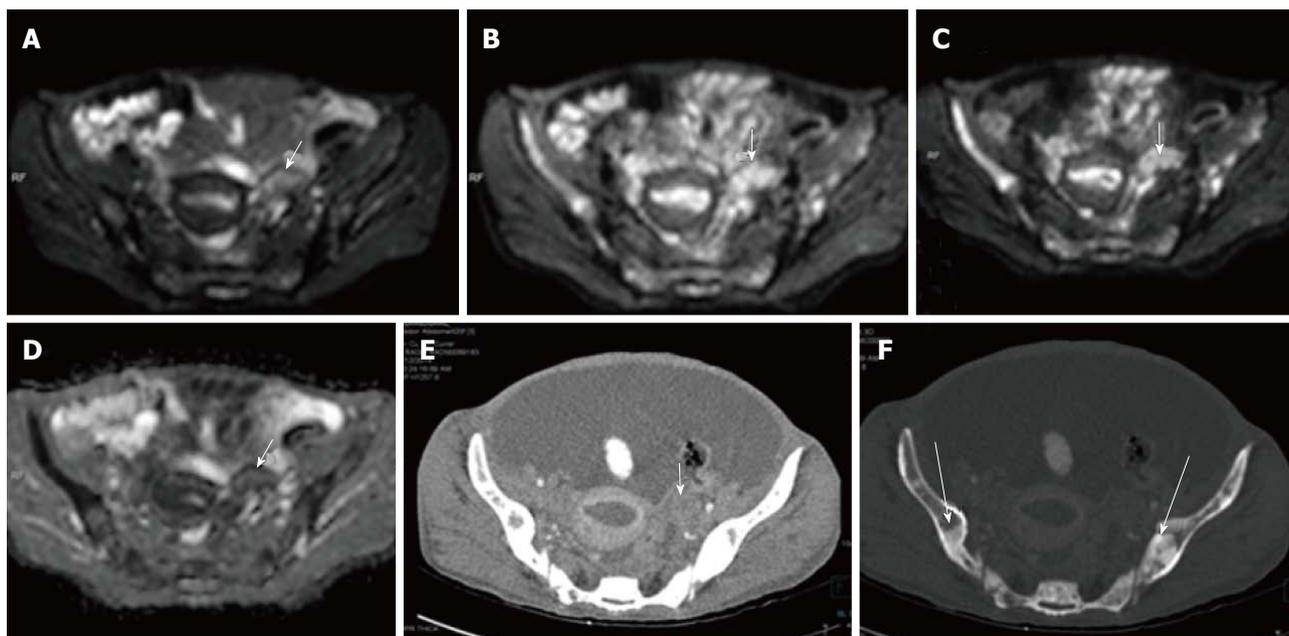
Left ovarian metastasis. Axial diffusion weighted imaging b 0 (A), b 400 (B), b 800 (C) and ADC (D) images of known case of carcinoma breast shows significant restricted diffusion of the left ovarian mass (arrow) suggesting left ovarian metastasis. Note is also made of multiple hypointense diffusion restricting lesions in the b/liliac bone which were metastatic deposits. Axial contrast enhanced CT (E) showing the left adnexal mass (arrow) with multiple sclerotic metastases (thick arrows) in bilateral iliac bones better seen on CT bone window image (F). ADC: Apparent diffusion coefficient; CT: Computed tomography.
